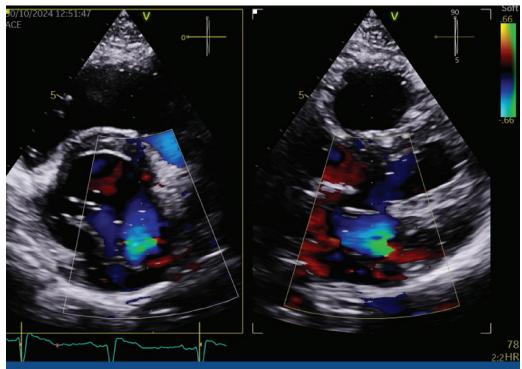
Parasternal biplane short axis views showing an extremely eccentric mitral regurgitation jet.
